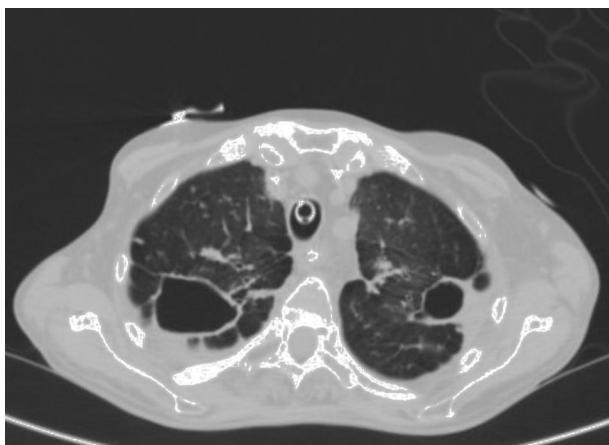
Chest computed tomography: fibrocavitory tracts in both upper fields, with signs of air trapping, panlobular emphysema, nodular opacities in both lungs, and bilateral pleural thickening.
